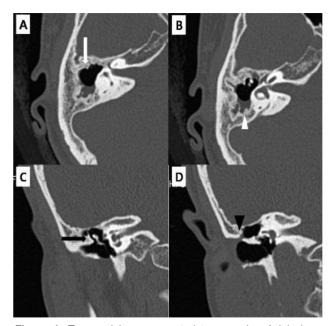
Temporal bone computed tomography. Axial view; A, B: Widened aditus and an example of the automastoidectomy state (white arrow) with cholesteatoma material remaining in the automastoidectomy cavity (white arrow head). Coronal view; C: Blunted scutum with widened Prussak space (black arrow). D: Possible previous antro-cutaneous fistula (black arrow head).
